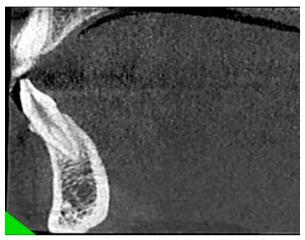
CBCT Sagittal view of lower left lateral, shows type III canal configuration.
